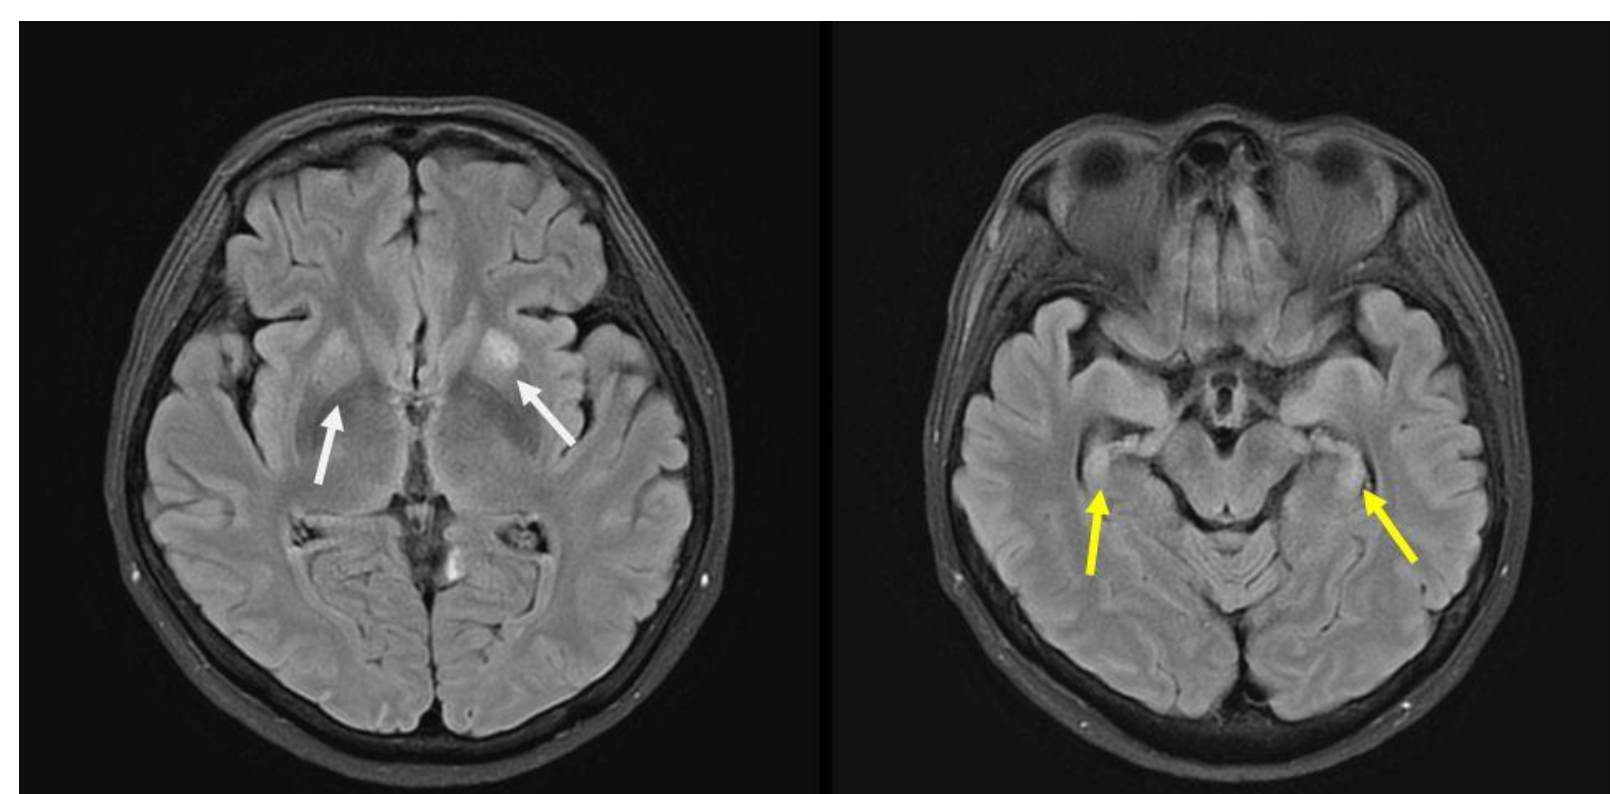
T2-weighted fluid attenuated inversion recovery image shows high signal intensity on both anterior basal ganglia (white arrow) and both hippocampi (yellow arrow).
